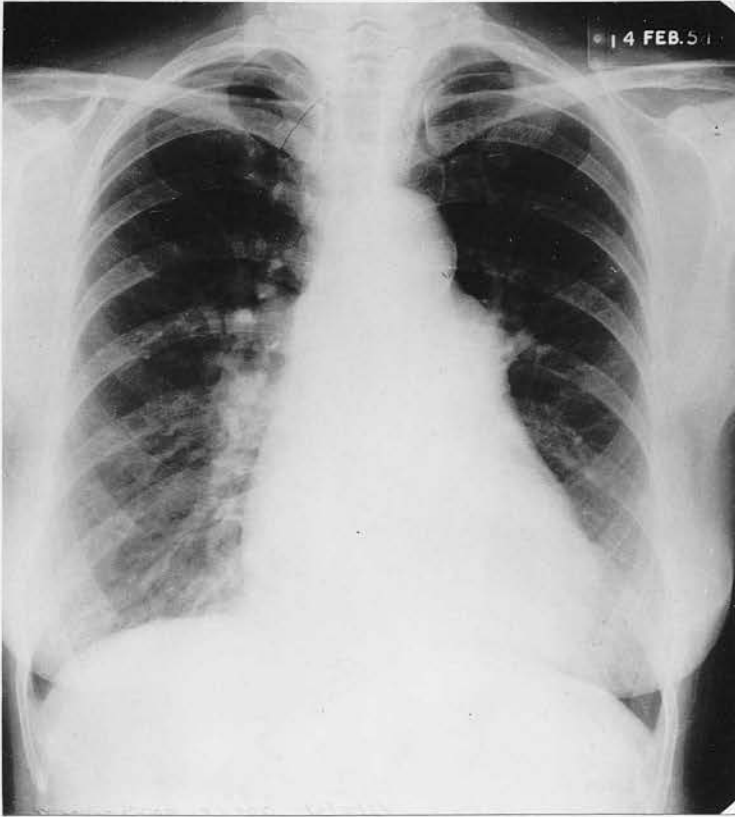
Radiograph of Case 73. Characteristic appearance of Patent Ductus in fifth decade.
